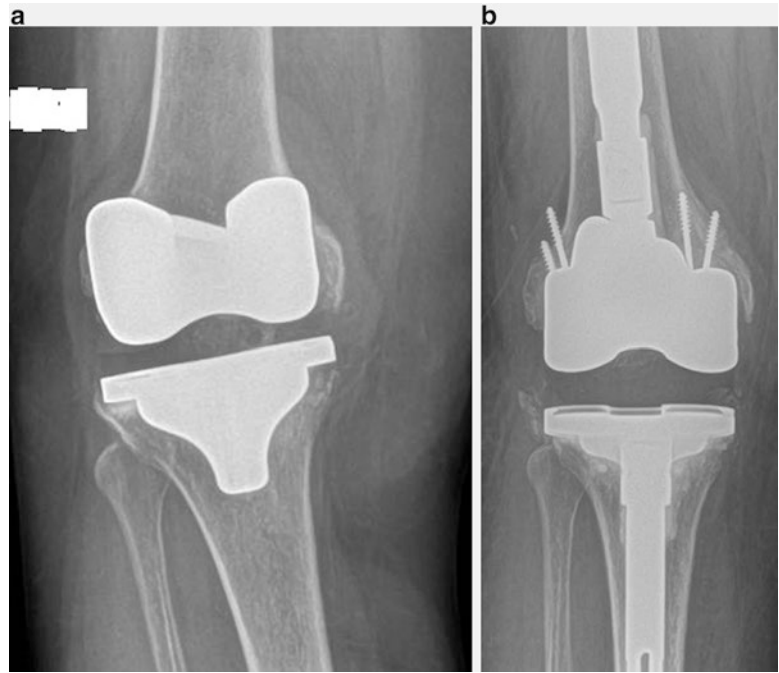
(a) Radiograph of a failed total knee arthroplasty, demonstrating medial tibial collapse with component lift-off on the lateral side. (b) This knee was reconstructed using a custom tibial component. (c) Radiograph of a failed total knee arthroplasty with similar failure mechanism. (d) Tibia was able to be reconstructed with use of a metaphyseal sleeve and long uncemented stem
